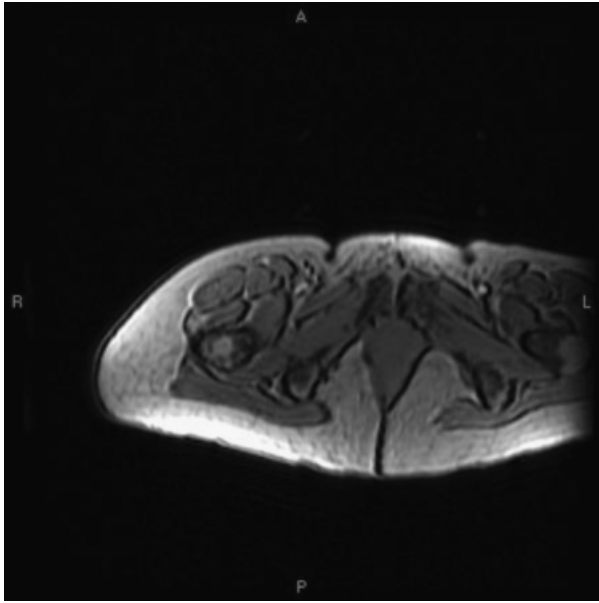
Pretreatment MRI.
